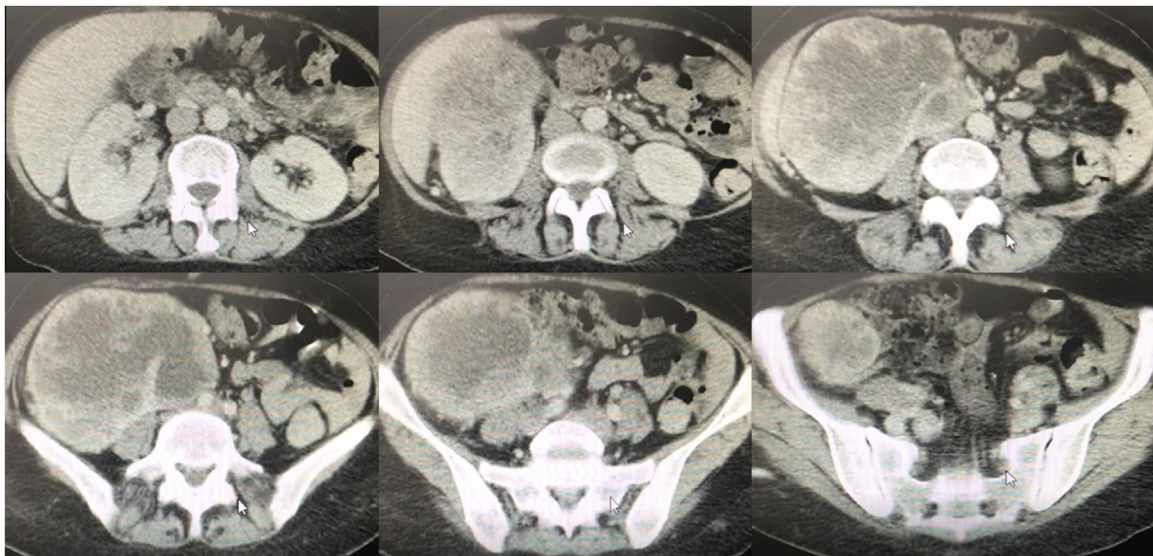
Abdominal Computed Tomography – ccRCC.
